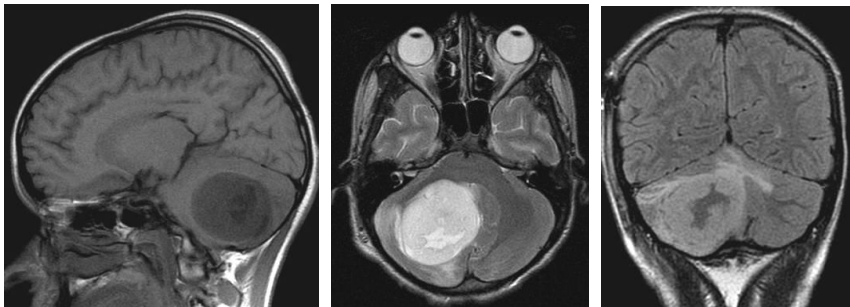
Right cerebellar hemisphere pilocytic astrocytoma – T1 and T2 MRI.
